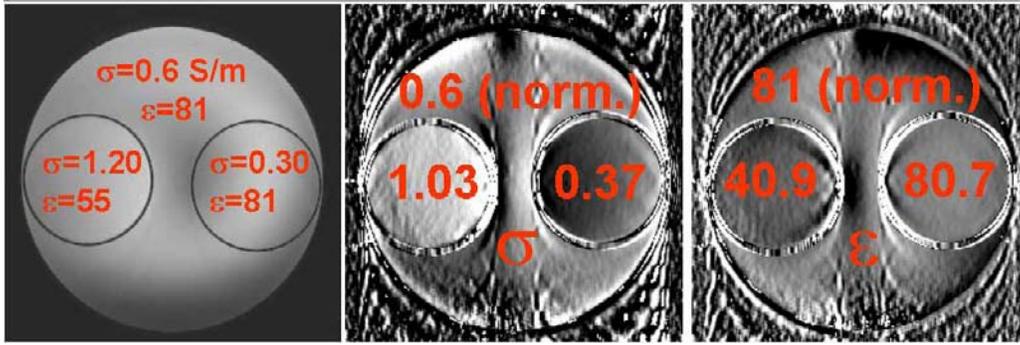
Raw MR image for  $\alpha=90^\circ$ . The left compartment contains an ethylenglycol solution (modified  $\sigma$  and  $\epsilon_r$ ), the right compartment a saline solution (modified  $\sigma$ ). Fig. 2: Reconstructed electric conductivity. The average values in the two inner compartments are normalized to the outer region. Fig. 3: Reconstructed permittivity. The average values in the two inner compartments are normalized to the outer region.
